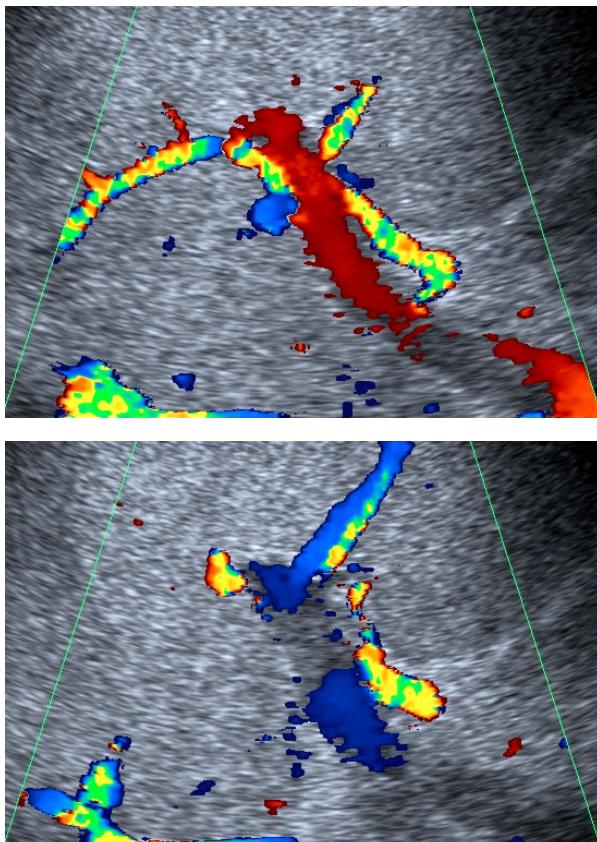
Doppler ultrasound in sinusoidal obstruction syndrome. Exemplary case showing undulating portal venous flow in a jaundiced patient after HSCTx
